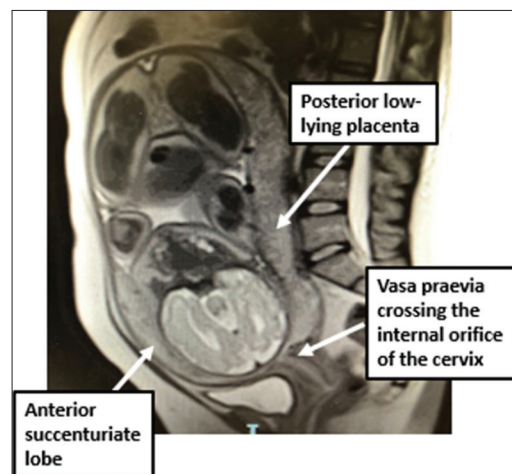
Complementary study with magnetic resonance imaging showing a sagittal section of the cervix revealing a posterior low-lying placenta and an anterior succenturiate lobe
